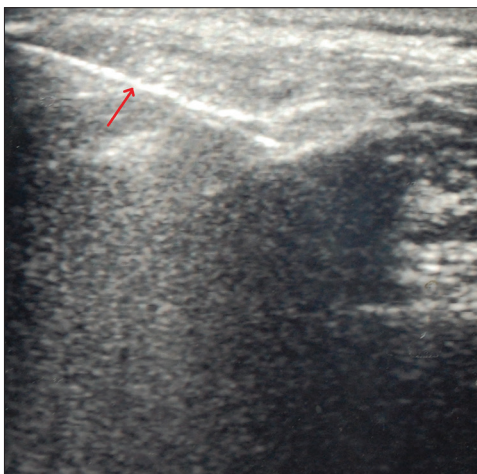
Ultrasound image showing needle in the joint cavity as a hyperechoic line
